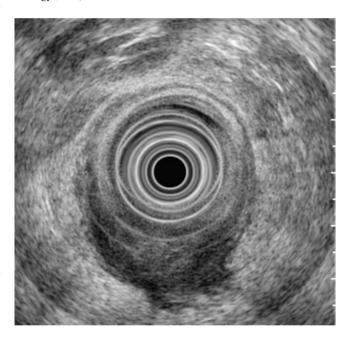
Endorectal ultrasound of T3 tumor. (Courtesy of Lehel Somogyi, MD)
